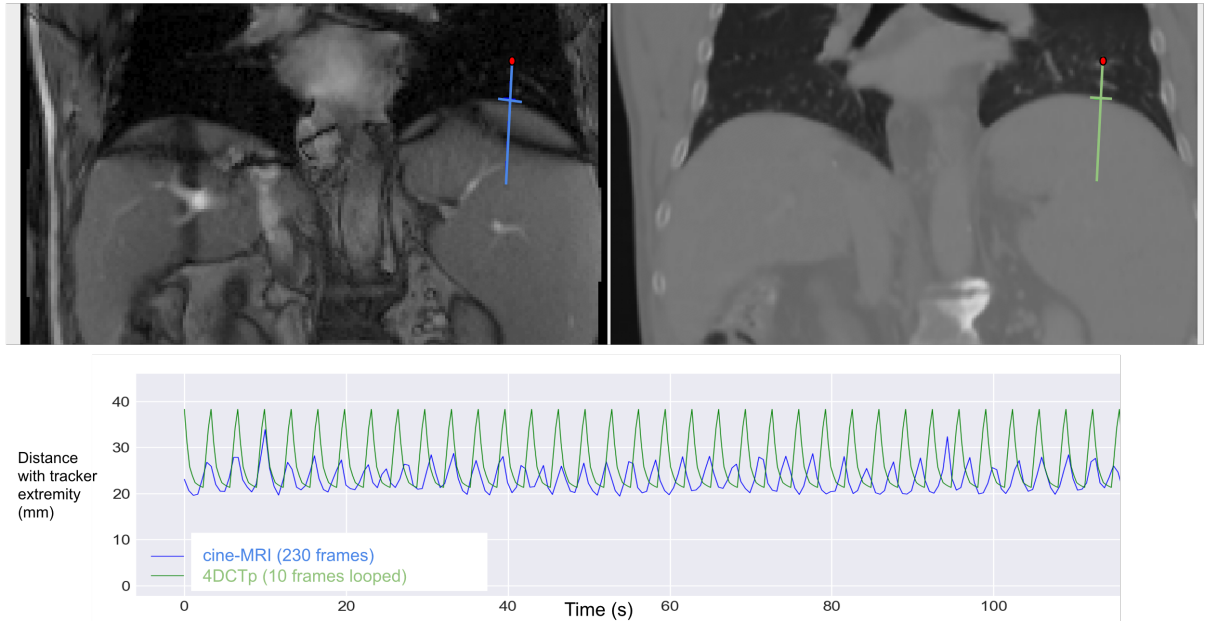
Example of area selection by placing a tracker on the left diaphragmatic dome for a cine-MRI sequence (left) and the corresponding slice of the 4DCTp (right). The resulting motion signals are given as the distance between the tracker’s extremity (red dot) which corresponds to 0 in the graph and the tracked border (small perpendicular line). We can see that the motion of the diaphragm at this position was around 20 mm in the 4DCTp, but when the patient came for the cine-MRI acquisition its breathing was less deep, and the motion was slightly under 10 mm.
